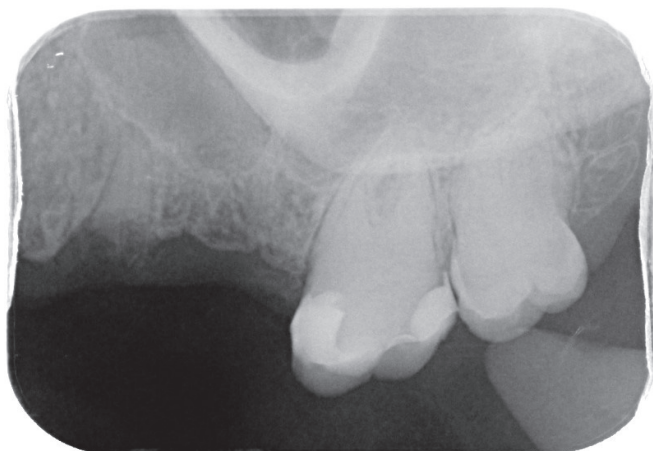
Periapical radiographs showing obliteration of pulp chambers and root canals
